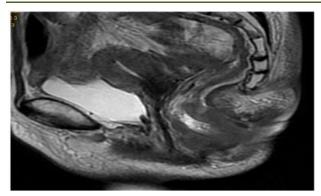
Pelvic MRI showing the tumor process
